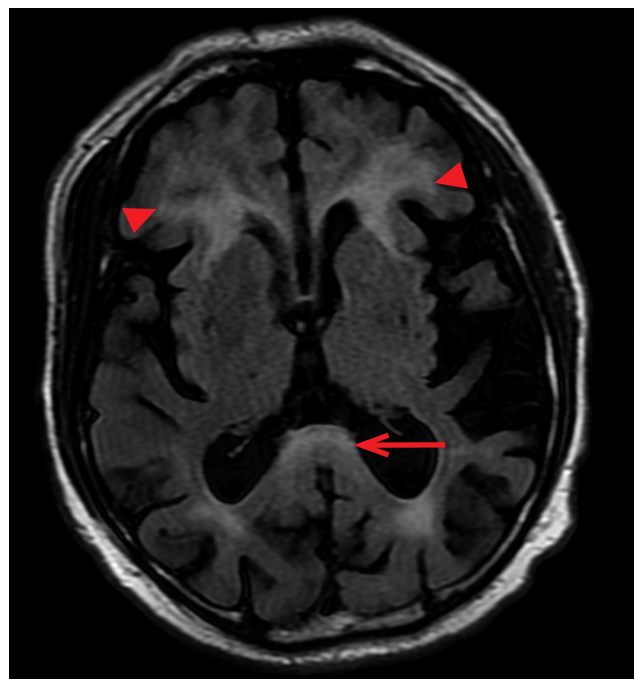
Hyperintensity in the area of the splenium of corpus callosum in a series of FLAIR (long arrow), additional finding — foci of symmetrical periventricular leukoaraiosis near the anterior horns (short arrows).
